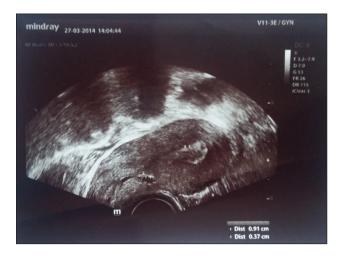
Ultrasound evaluation. Scar insufficiency
